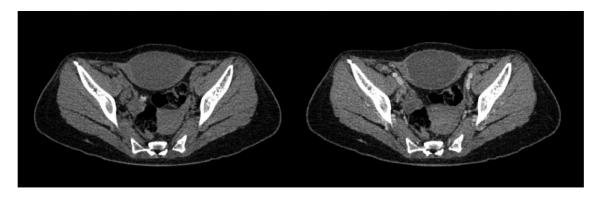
Abdominal CT showed a hypodense mass anterior to pubic tubercles with peripheral enhancement following intravenous contrast administration.
